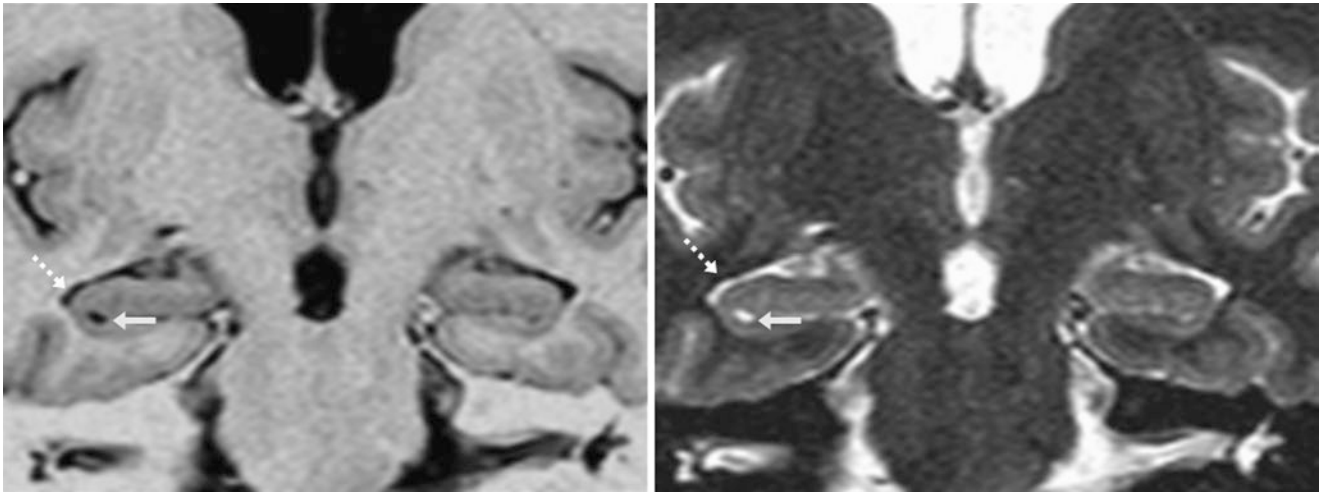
A 27 year old was given a 1.5 T MRI that depicted a tiny right hippocampal cyst (*arrows*) with a signal intensity of CSF on thin coronal T1 IR (*left*) and T2 IR (*right*) images. Note the temporal horn of the lateral ventricle (*dashed arrows*)
